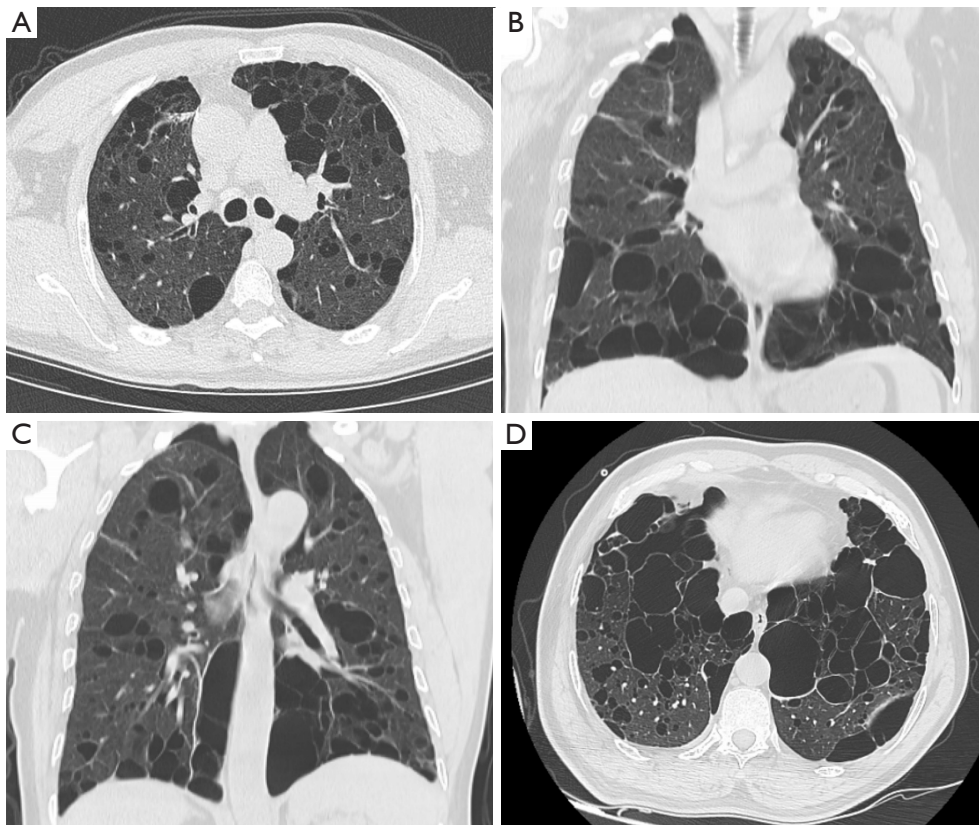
Chest computed tomography (CT) of case A. (A) Axial CT shows pulmonary cysts, mainly distributed in the subpleural regions. (B) A coronal CT scan showing multiple cysts with a basal predominance distribution. (C) A coronal CT scan showing fusiform pulmonary cysts near the spine of both lower lungs. (D) For the multiple pulmonary cysts in the basal segment of both lungs, the diameter of most cysts is >2 cm.
